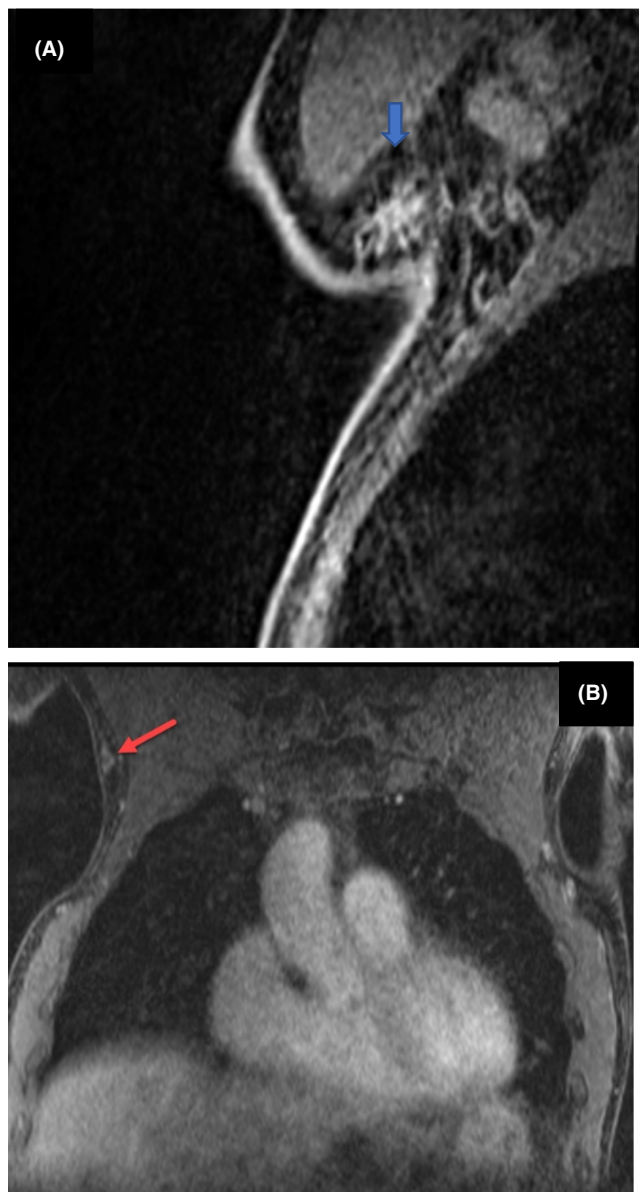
(A) Representative T1 fat saturated post-contrast sagittal breast MRI image demonstrating the irregular enhancing mass in the right axilla. (blue arrow). (B) MRI coronal view of the thorax demonstrating an irregular enhancing axillary mass on post-contrast views (red arrow)
